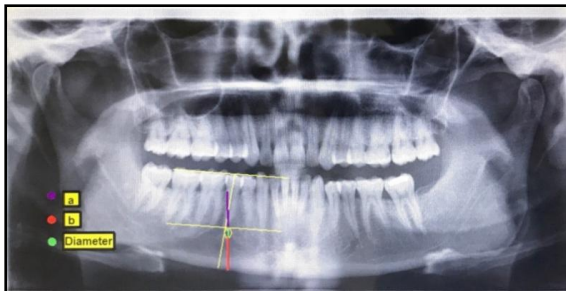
Measurements in orthopantomogram radiograph for age estimation
